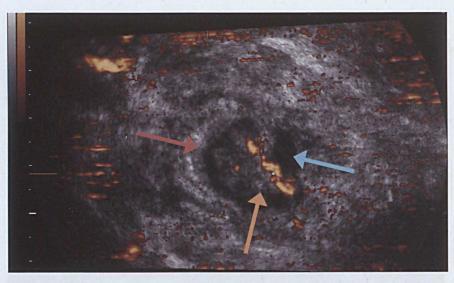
Experimental Design 2. Transverse image of thirddegree haemorrhoids, acquired using 3D power Doppler.
